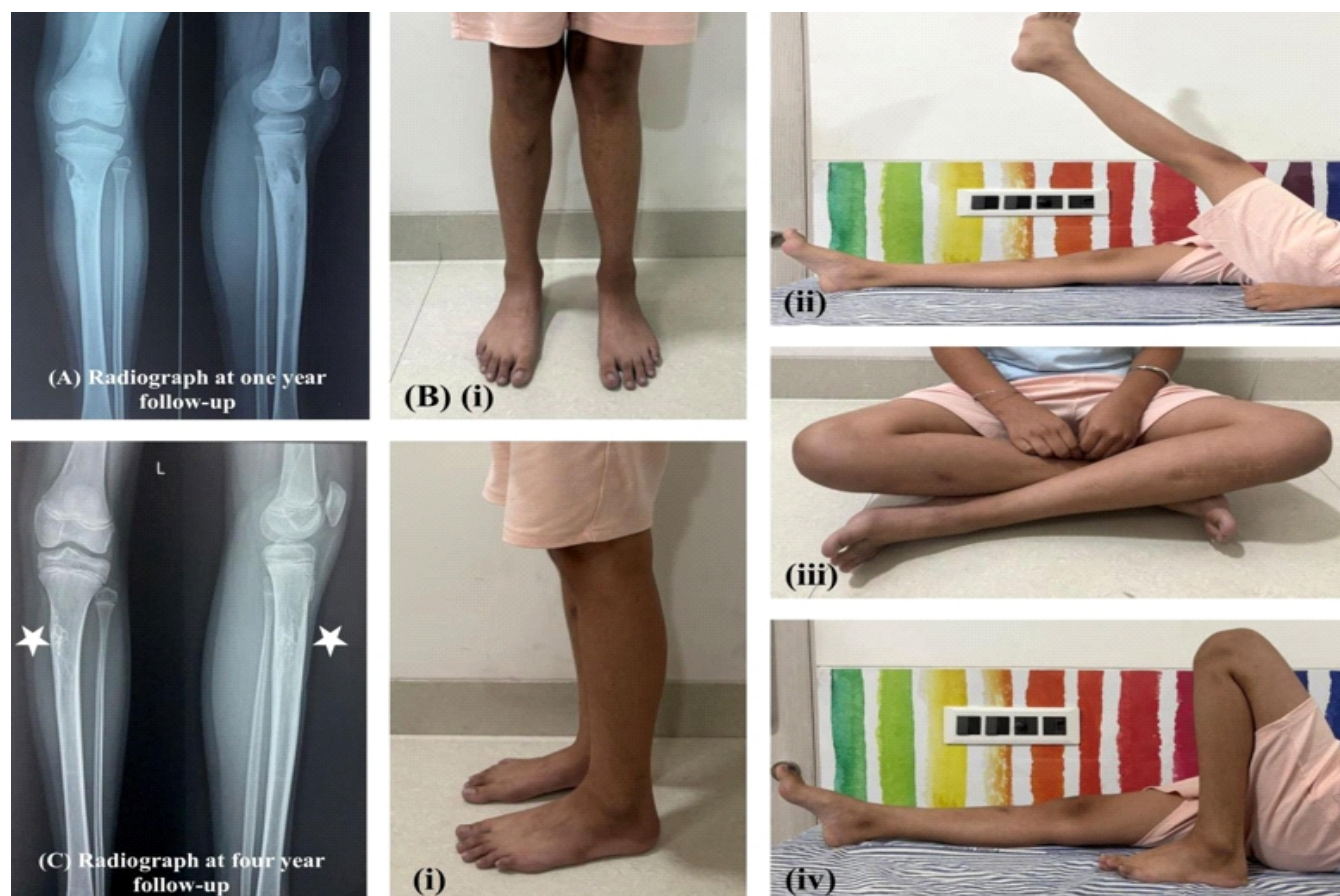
(a) One-year follow-up radiographs demonstrating progressive graft incorporation and lesion healing. (b) Clinical photographs at 4-year follow-up showing (i) standing, (ii) active leg raise, (iii) cross-leg sitting, (iv) Full knee flexion. (c) Anteroposterior and lateral radiographs of the left leg at 4-year follow-up showing complete healing of the lesion with graft incorporation (white asterisk) and excellent remodeling.
